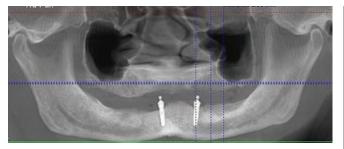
B, Panoramic radiograph taken with cone-beam scanner to document current bone levels.
